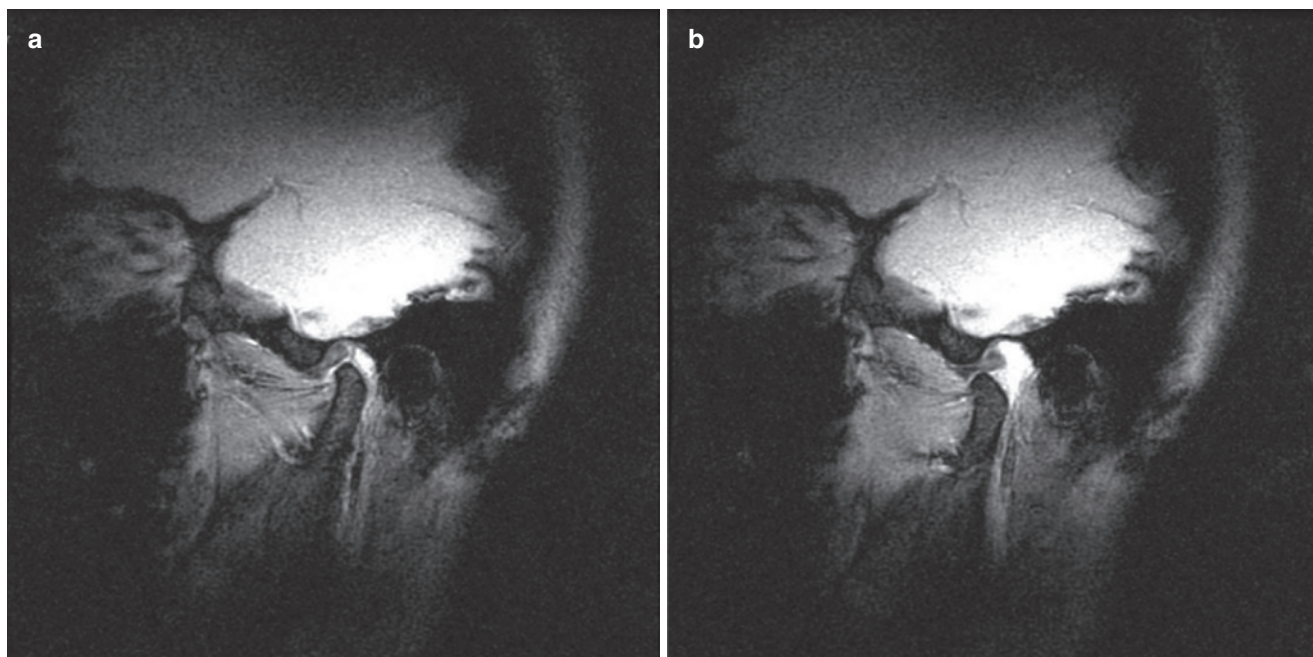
(a) TMJ MRI in closed mouth view with normal anatomic position of the articular disc. (b) TMJ MRI in open mouth view with normal anatomic relationship between the articular disc, eminence, and condyle
